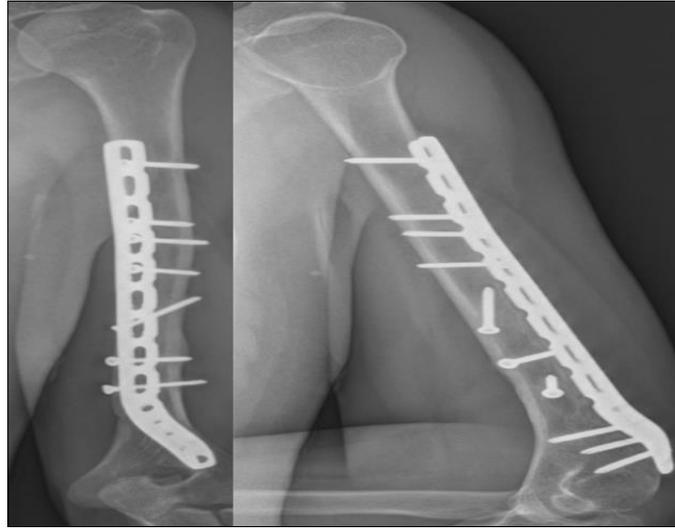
Postoperative radiograph at 10 weeks of follow up
